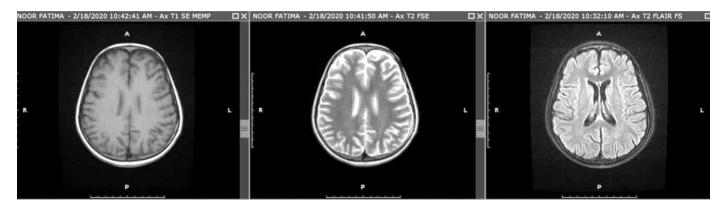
Axial MRI images at the level of third ventricle showing no abnormality.
